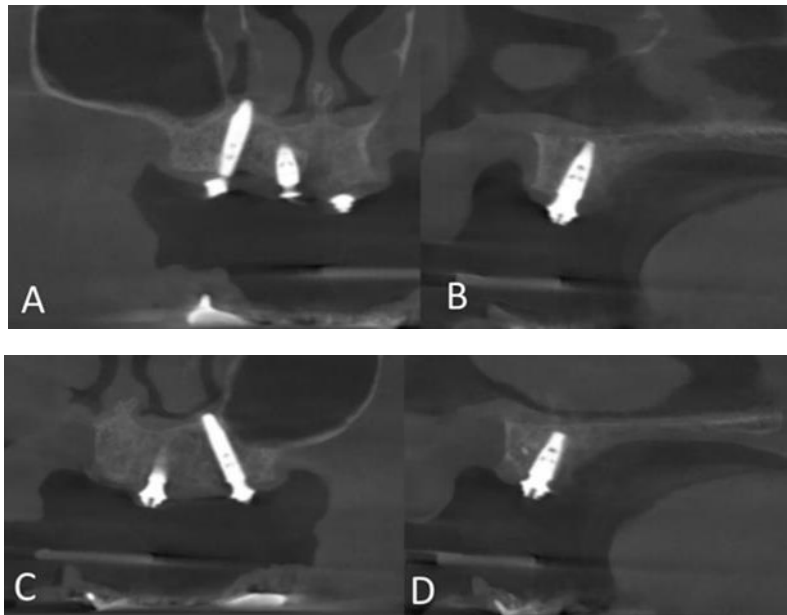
Postoperative CBCT. Tomographic sections showing the implants in regions 15 (A), 11 (B), 21 (C) and 25 (D).
